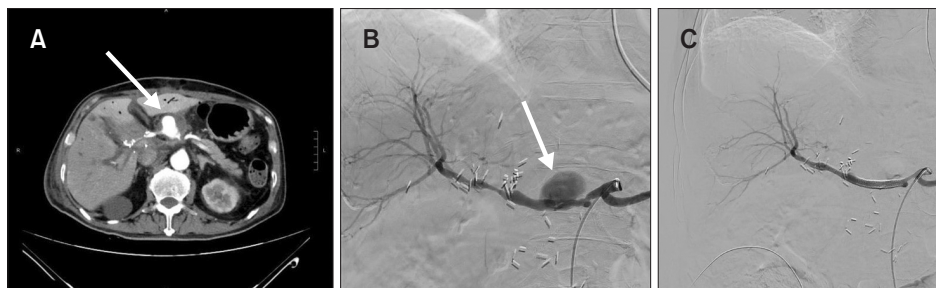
Images for Case 3. (A) Computed tomography showed an ≤ 3 cm saccular pseudoaneurysm over the proximal common hepatic artery (arrow). (B) The pre-treatment celiac angiography showed a pseudoaneurysm over the proximal common hepatic artery, with no features of active bleeding (arrow). (C) The celiac angiography after the deployment of flow diverters and a covered stent showed complete obliteration of the pseudoaneurysm and preservation of the arterial blood flow.
